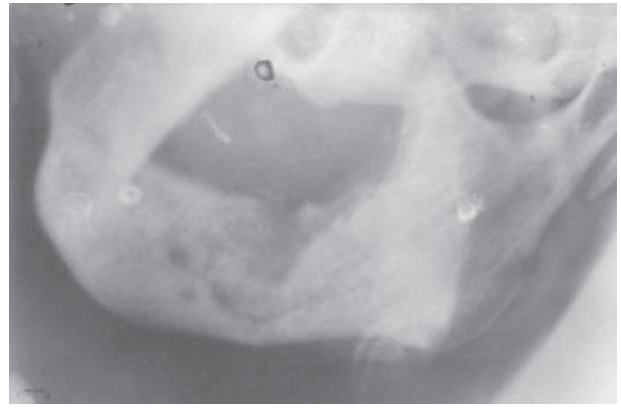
Radiograph revealing areas exhibiting moth eaten appearance.
